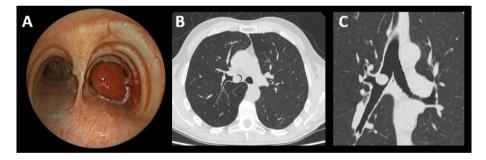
Bronchoscopic (A), axial (B) and coronal (C) CT images of a polypoid typical carcinoid in the right main bronchus.
